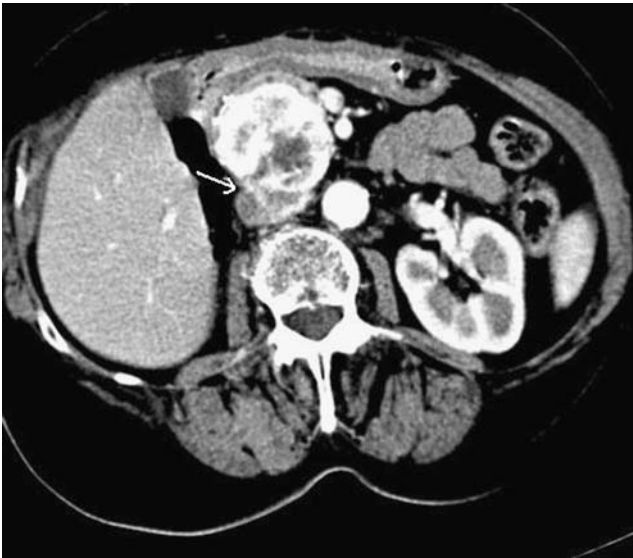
The abdominal CT scan showed a 5.0-cm mass in the head of the pancreas with a suspected involvement of vena cava (arrow).
